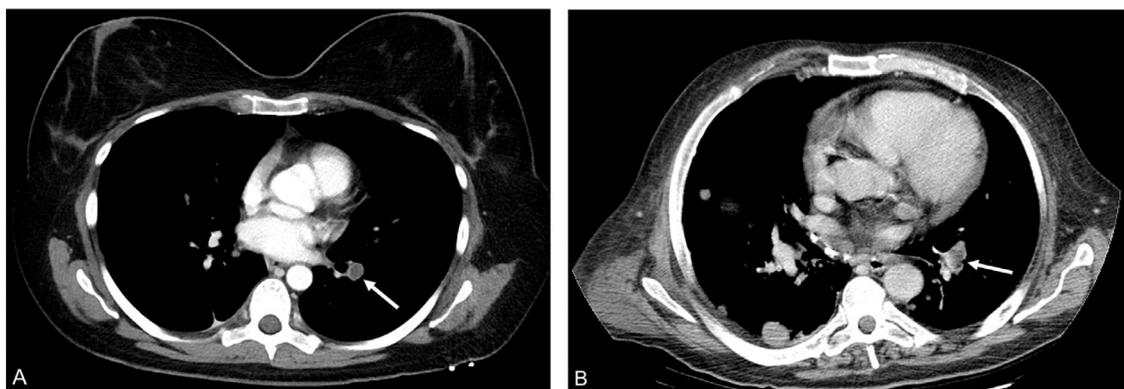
Missed pulmonary embolism (PE) on abdomen-pelvis (AP) contrast-enhanced CT (CECT). (A) A 37-year-old woman with acute abdominal pain. The missed left lower lobe PE (white arrow) was evident on the first slice of this AP CECT. This finding was incidental. (B) A 70-year-old man with colon cancer and abdominal pain. This left lower lobe PE (white arrow) was missed by the on-call resident. Detection is difficult because of the portal venous phase of imaging.
